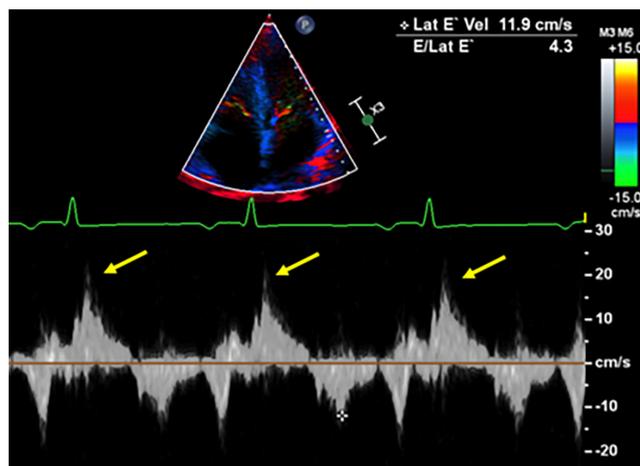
Pickelhaube sign with a spike-like tissue Doppler signal (yellow arrows), reflecting rapid acceleration of the lateral mitral annulus toward the left ventricular apex during systole due to prolapse of the posterior mitral valve leaflet in Case 1.
